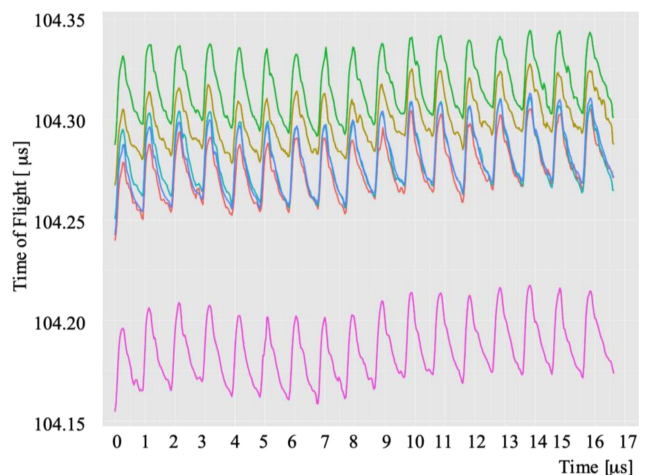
Typical multispectral ultrasonic curves – here the 6 different frequencies, simultaneously recorded and plotted as the time of flight (ToF) curves. With the scanning system that was used, a maximum of 10 different frequencies can be sent and received at once. The signal sampling is 50 measurements per second (50 MPS).
